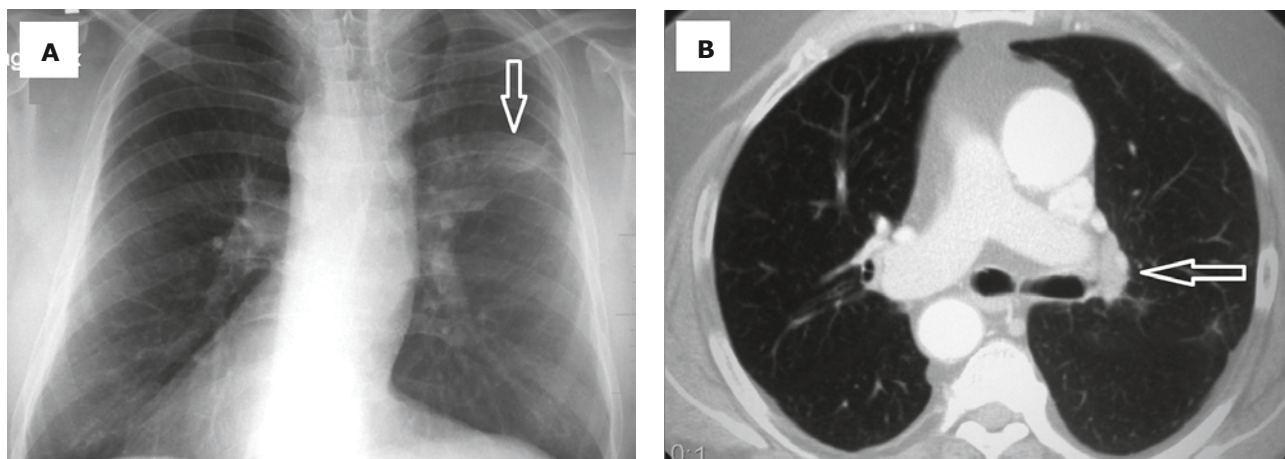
A. Chest X-ray shows mirror image and infiltration of the left upper field (arrow). B. Chest computed tomography with the mirror image and left lung hilum infiltration (arrow)
